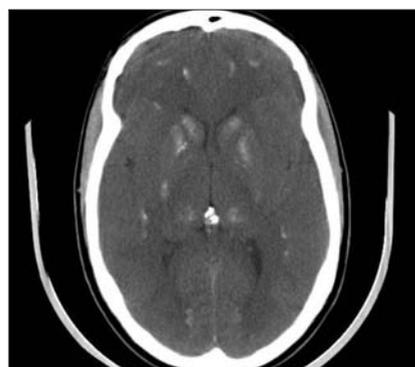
Non-contrast enhanced CT scan through the mid portion of the brain, with enhancing lesions in the frontal, parietal and occipital lobes as well as the subcortical matter, thalamus and basal ganglia.
